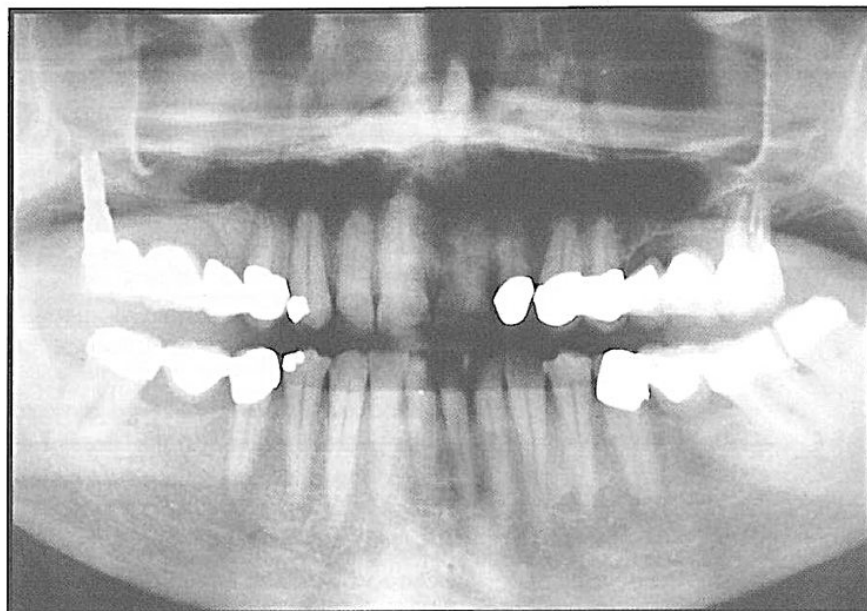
Postoperative panoramic radiograph of the final tissue-integrated prosthesis. The mandibular right fixed partial denture awaits replacement.
